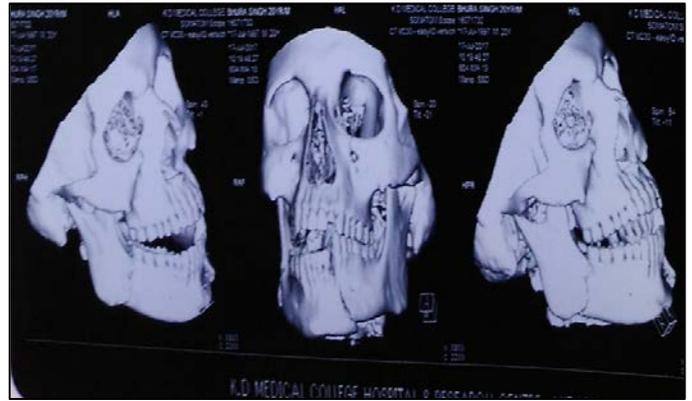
Pre-operative 3D reconstruction CT Scan showing right angle & left parasymphysis fracture.
